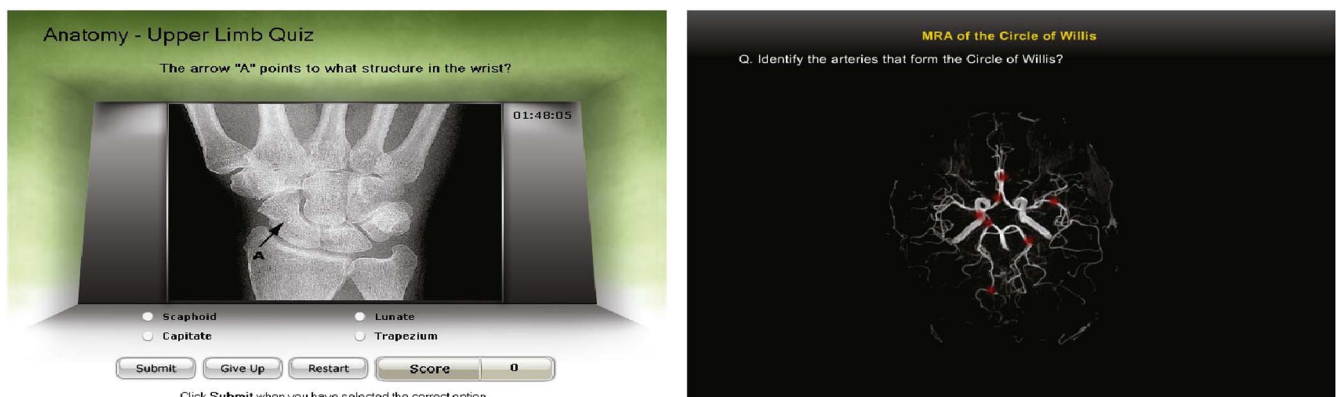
Examples of medical games: X-ray (left) and MRI (right): Philips Learning Connection [26,28] Font: <http://www.theonlinelearningcenter.com/free-online-medical-games.aspx>.
